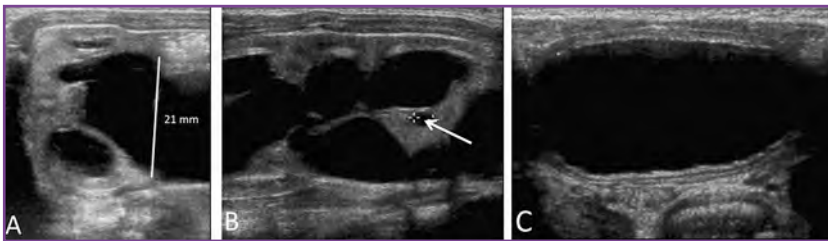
Urinary tract dilation grade P₃ ultrasonographic (US) appearance. A, Transverse US exhibits anteroposterior renal pelvic diameter of at least 15 mm, with peripheral dilation of the calyces. B, Sagittal US exhibits parenchymal thinning and cysts (arrow). C, Bladder US demonstrates increased wall thickness.
